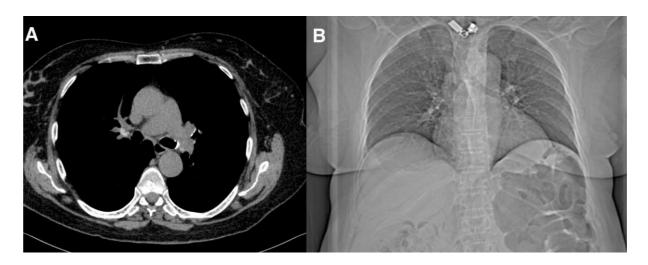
Chest CT in Case 2.
